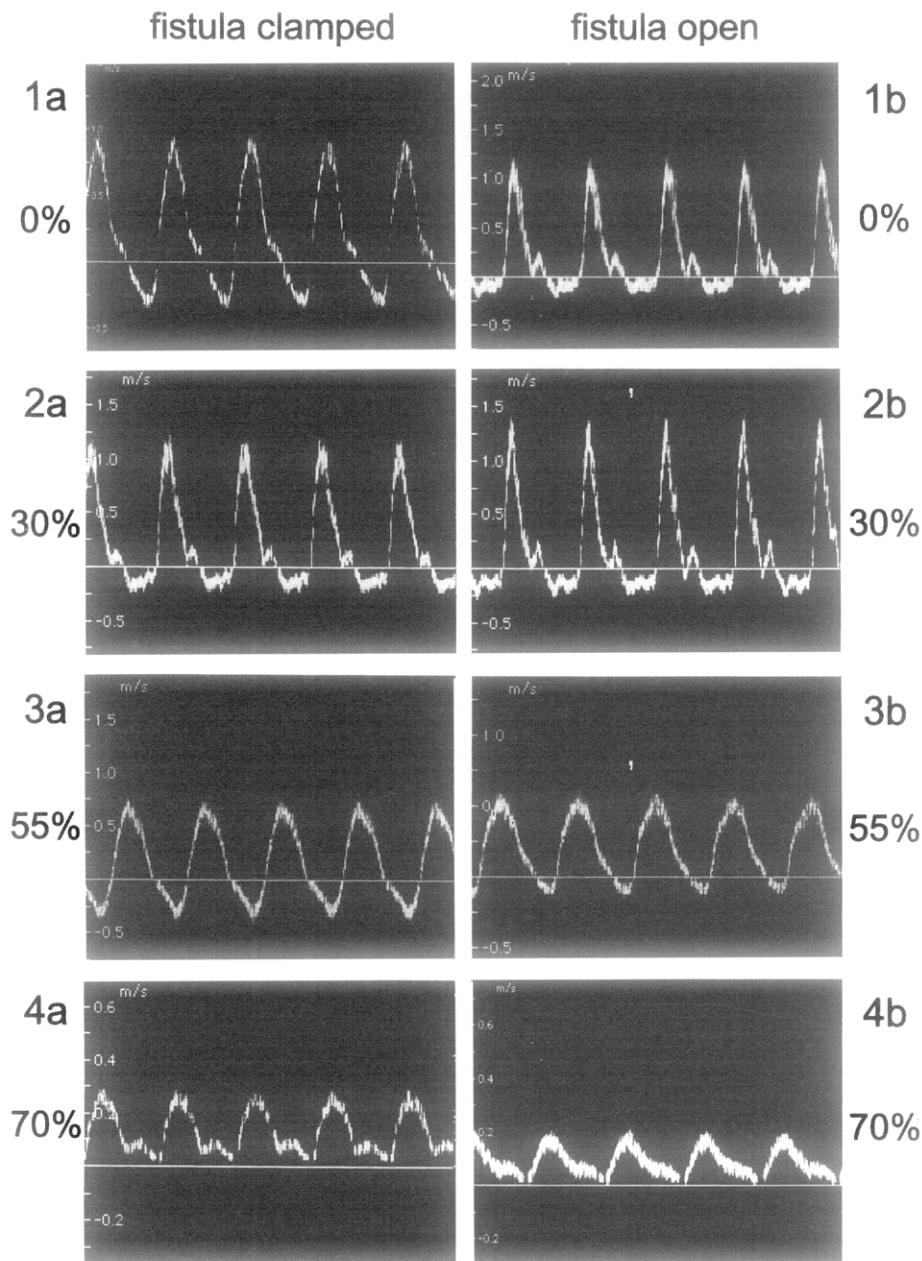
Distal spectral Doppler waveforms. *1a*, 0% stenosis without fistula, *1b*, 0% stenosis with fistula, *2a*, 30% stenosis without fistula, *2b*, 30% stenosis with fistula, *3a*, 55% stenosis without fistula, *3b*, 55% stenosis with fistula, *4a*, 70% stenosis without fistula, *4b*, 70% stenosis with fistula. Severity of stenosis is stated as percentage diameter reduction.
